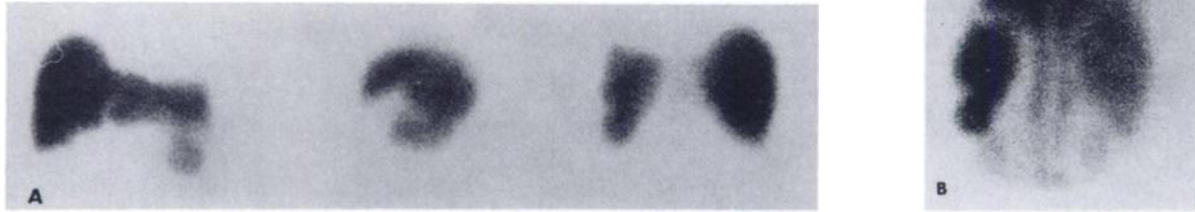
Female, age 81, with left upper quadrant pain. (A) Anterior, left lateral and posterior views with TcSC suggest splenic defect near lower pole. Considerable overlap of liver and spleen, however, raises possibility of "pseudodefekt." (B) posterior scintigram with Tc-RBC clearly shows splenic defect. (This was an early study, using an incubation period of 15 min; insufficient RBC damage resulted in incomplete sequestration by the spleen, and high blood-pool activity. Note that this does not interfere with the diagnostic value of images.)
